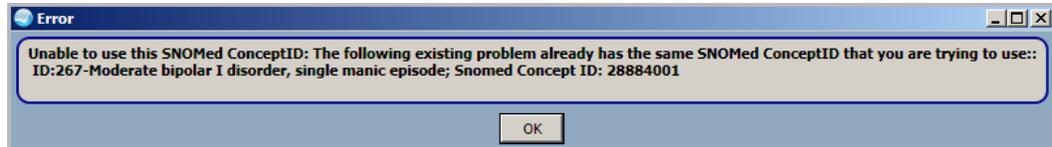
Duplicate SNOMED CT Code Error Message
